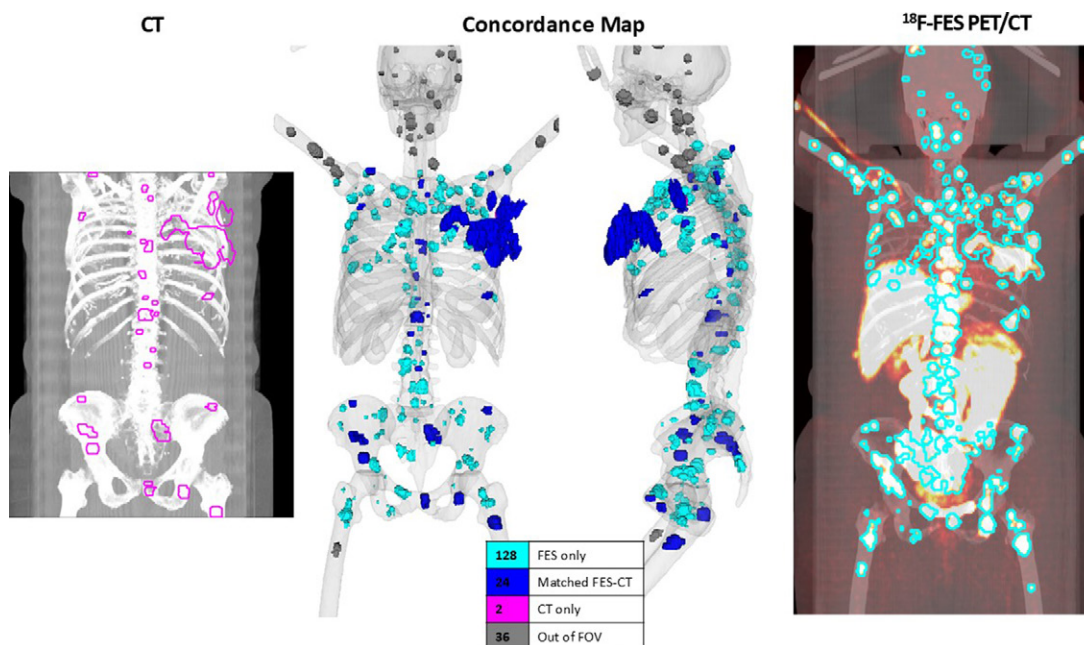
In one selected participant, the automated concordance tool (center) highlights 24 lesions (dark blue) that were found in both the standard-of-care CT image (left) and fluorine 18 (^{18}F)-fluorodeoxyglucose (FES) PET/CT image (right); 128 lesions (light blue) were identified with only the ^{18}F -FES PET/CT, and two lesions were found with only the standard-of-care CT. Seven lesions were outside of the CT field of view (gray).
